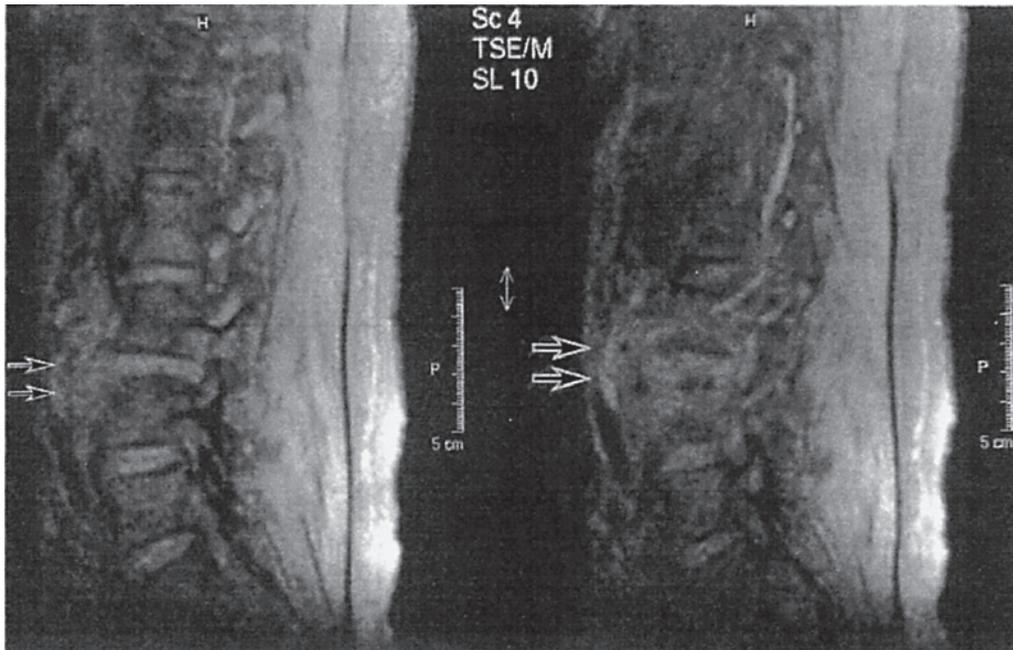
MR imaging (T₁-weighted MR images) showed an acute abscess formation with gas formation in front of the L3/4 vertebral bone(→). (CASE 3)
